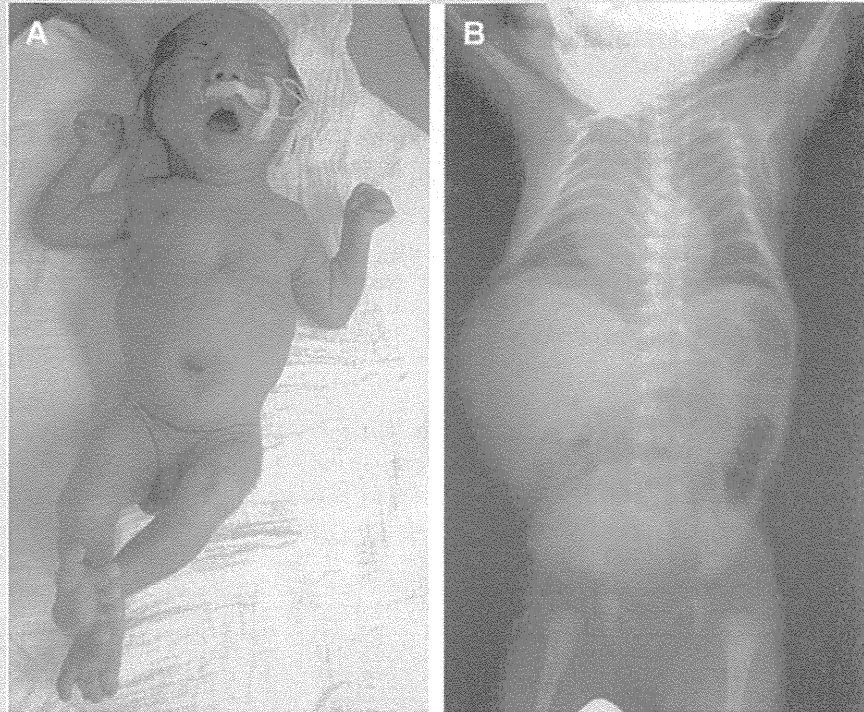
Postnatal findings at 1 month of age. A: Front view. B: Chest roentgenogram showing bell-shaped thorax with coat-hanger appearance of the ribs.
